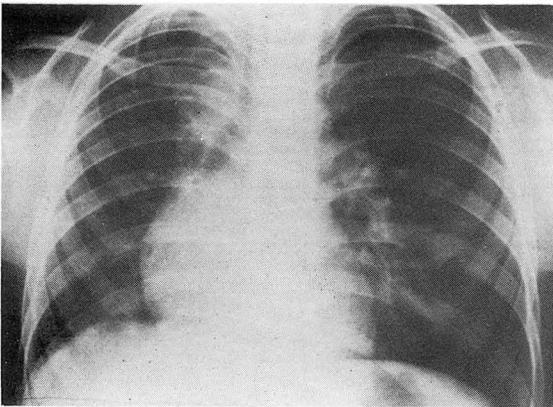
Chest roentgenogram showing mediastinal shift to the right and a small right lung. Right hilar vessels are obscured by the heart. Some decreased aeration is seen in the right upper lobe.
